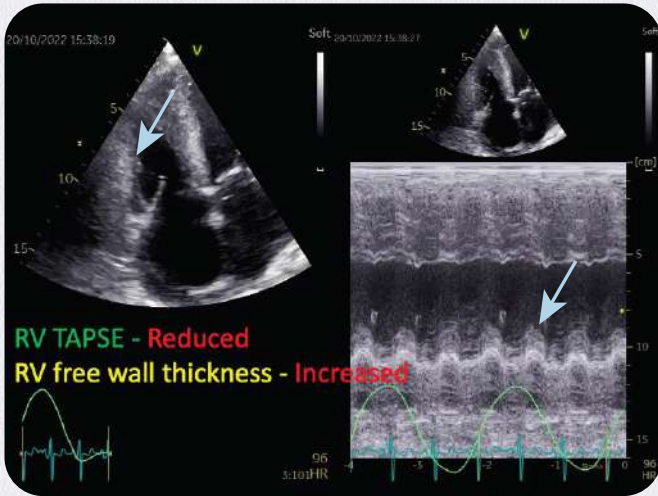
An echocardiographic image of the right ventricle (RV) seen in the RV-focused apical-4 chamber view. There is a thickening of the RV free wall (blue arrow).
